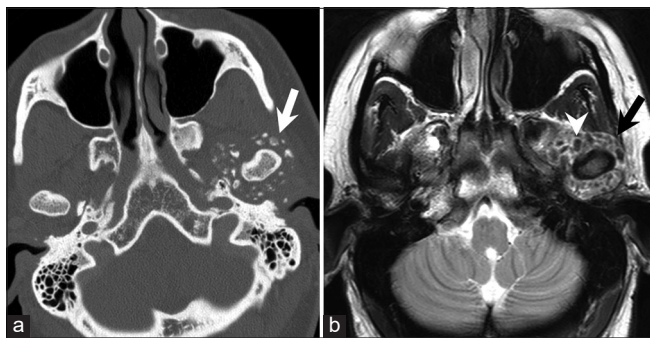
Synovial chondromatosis with calcified intra-articular loose bodies. A 50-year-old woman with synovial chondromatosis presenting with left jaw pain. Axial CT image in bone window (a) shows several small calcified intra-articular loose bodies in the left temporomandibular joint (arrow) which are hypointense on axial T2W MRI image (b) (arrowhead). Note diffuse synovial thickening and distension of the joint capsule (black arrow).
